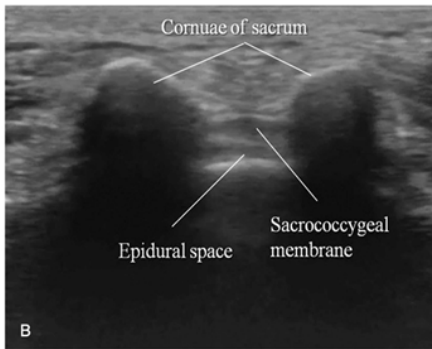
Sonographic image of the caudal space in transverse view.
